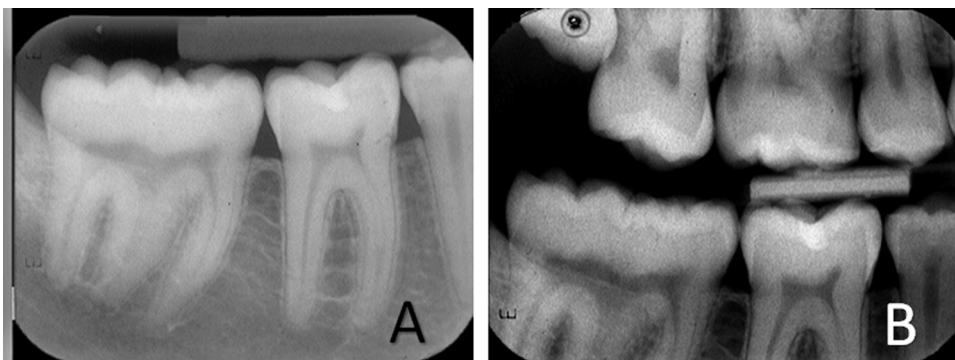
(A) Periapical radiography; (B) Bite-wing radiography.
